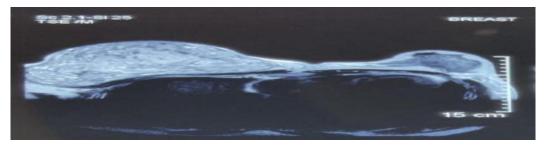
shows MRI image of a mass in breast with heterogenous signal intensity
